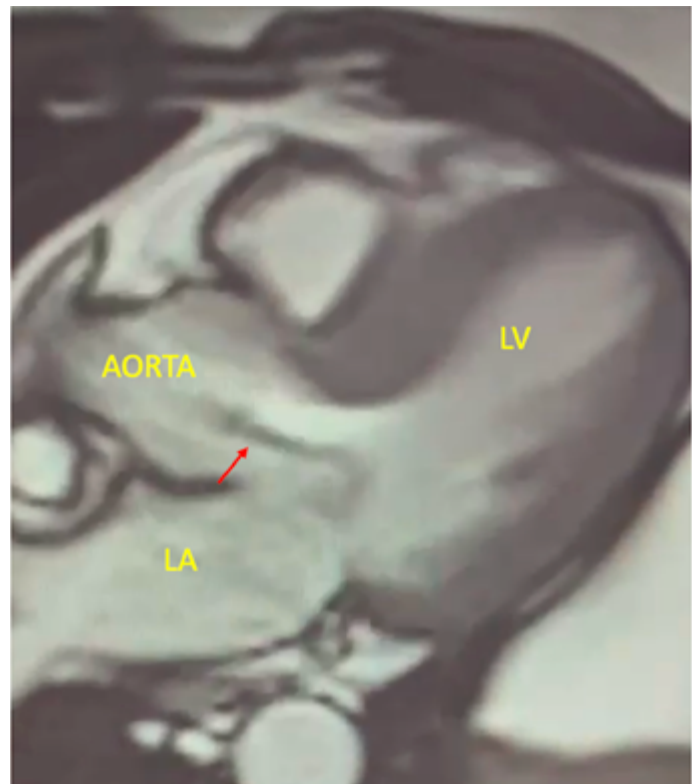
Cardiac MRI long axis projection of the 3-chamber view where accessory mitral valve tissue (red arrow) is seen extending from the anterior leaflet of the mitral valve to the LVOT (LV, Left Ventricle; LVOT, Left Ventricular Outflow Tract).
